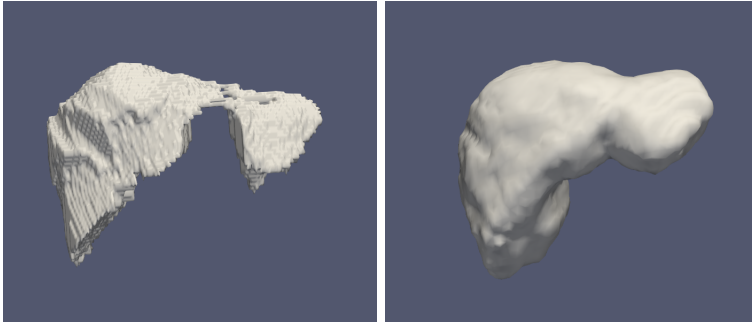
Liver segmentation from CT data, by thresholding, erosion, connected components labeling and refined by the GSUBSURF method.*
